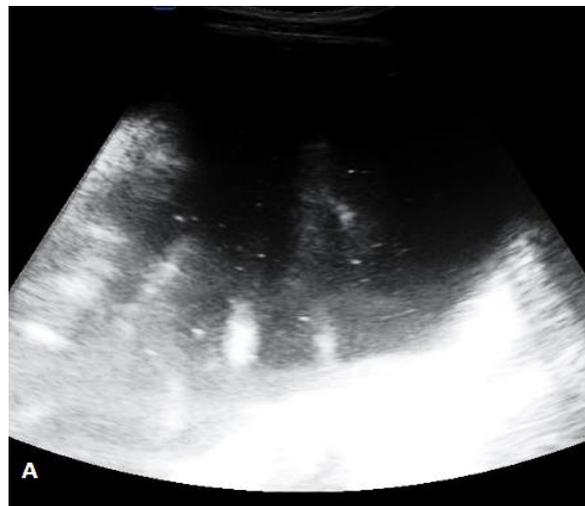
(A)Greyscale ultrasound of the abdomen and pelvis showing a large anechoic cystic lesion.
